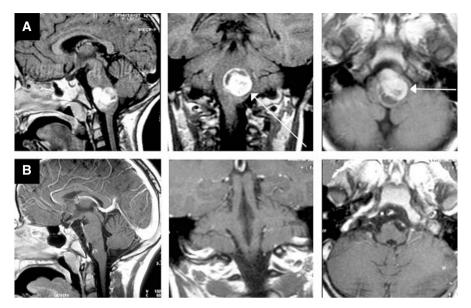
Preoperative (A) and postoperative (B) contrast enhanced sagittal, coronal and axial MR images revealing a giant intra-axial intramedullary pilocytic astrocytoma totally removed (from ref. 7). The arrows indicate how the tumor is growing towards the brainstem surface facilitating its exposure. In fact the tumor was completely removed through a low mini retrosigmoid approach and a short lateral longitudinal myelotomy in the medulla just below the exit of the lower cranial nerves. B MR images obtained 5 years after surgery show no tumor regrowth and a return to a normal physiological anatomy of the medulla. The 3-year-old child presented with facial and hypoglossus initial palsies, right hemiparesis, ataxia, dysphagia and dysphonia. All the neurological deficits resolved in a few months after surgery and the child is now living a normal life
